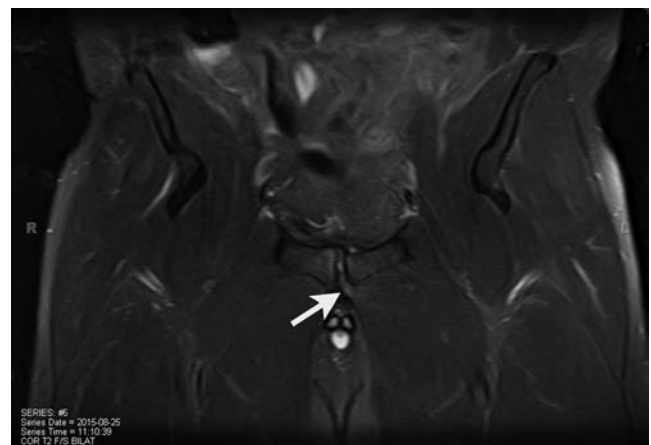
MRI of left adductor tear (arrow). The tear extends into the symphysis with evidence of a cleft.
